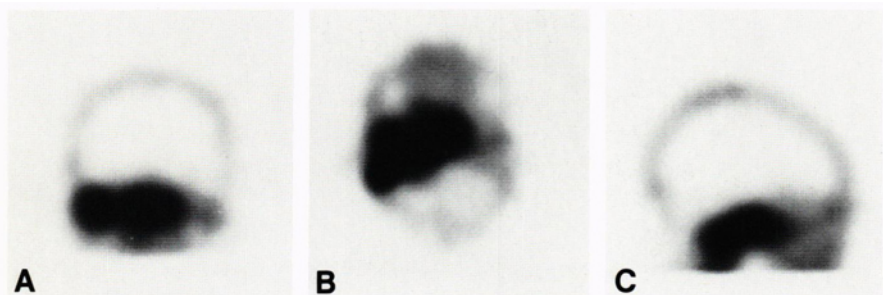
SPECT bone study demonstrating increased uptake of ^{99m}Tc -MDP extending across the midline of the skull. (A) coronal; (B) transaxial; (C) sagittal.
